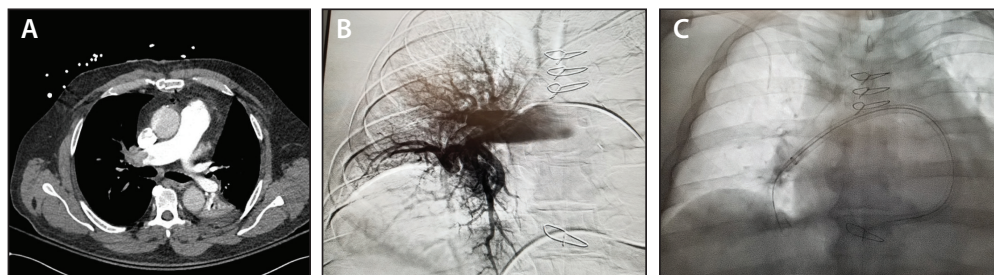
Diagnostic imaging. Initial CT confirming PE (A). Pulmonary angiogram confirming the significant thrombus burden in the right main PA (B). The positioned FlowTriever T20 catheter preaspiration (C).
